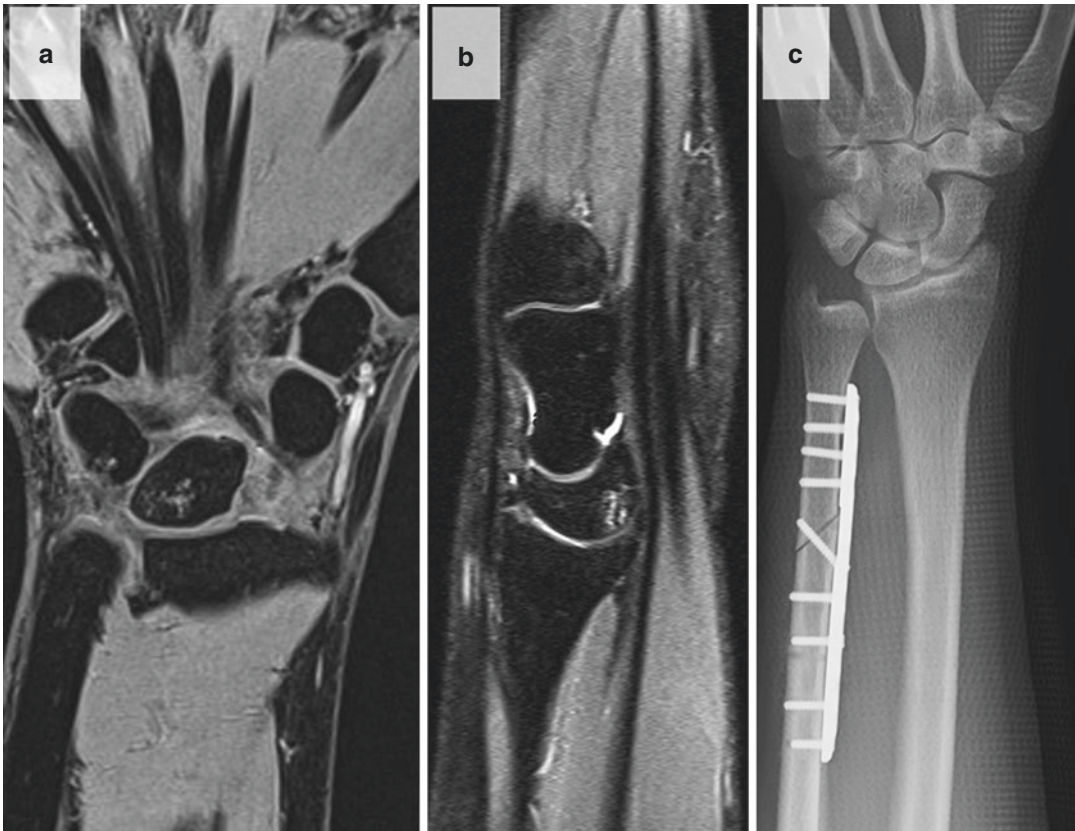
MRI (a, b) and X-ray (c, left wrist) of a 30-year-old female bouldering athlete who had reported long-lasting and consistent pain even after having received arthroscopic debridement of the TFCC 2 years earlier (positive ulna variance). An extended shockwave therapy
